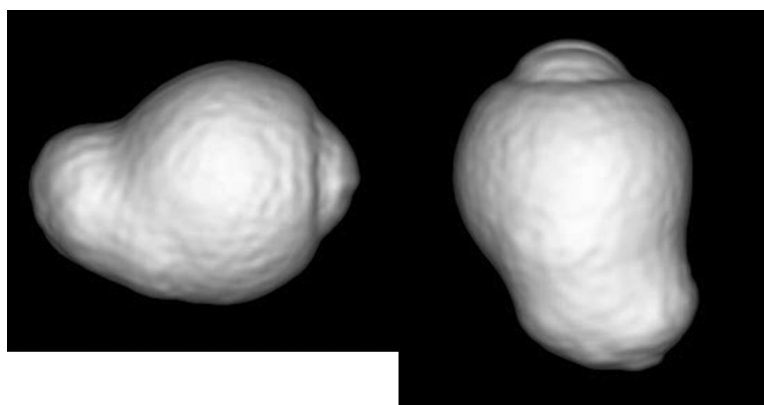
Three-dimensional MRI of the eye with posterior staphyloma. A clear outpouching of a part of the posterior segment of the eye is observed in the image viewed from the side (left) as well as in the image viewed from the inferior (right).
